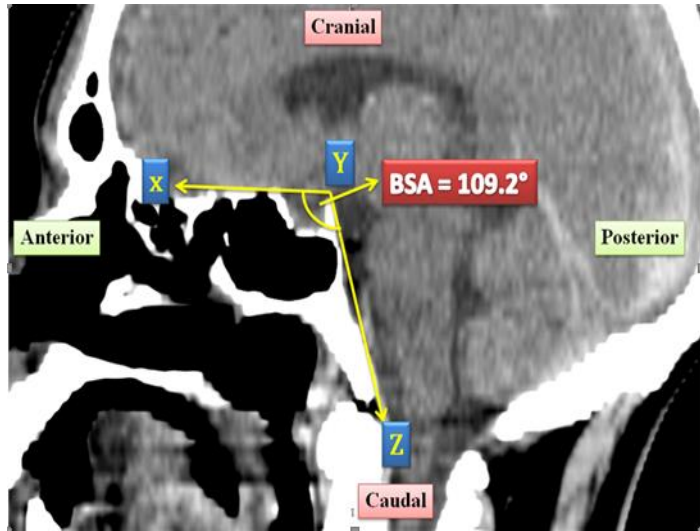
Sagittal slide of sphenoid sinus CT of a 51-year-old female showing sphenoid flexion and landmarks of measurements of the basal sphenoid angle, between lines XY, and YZ.
